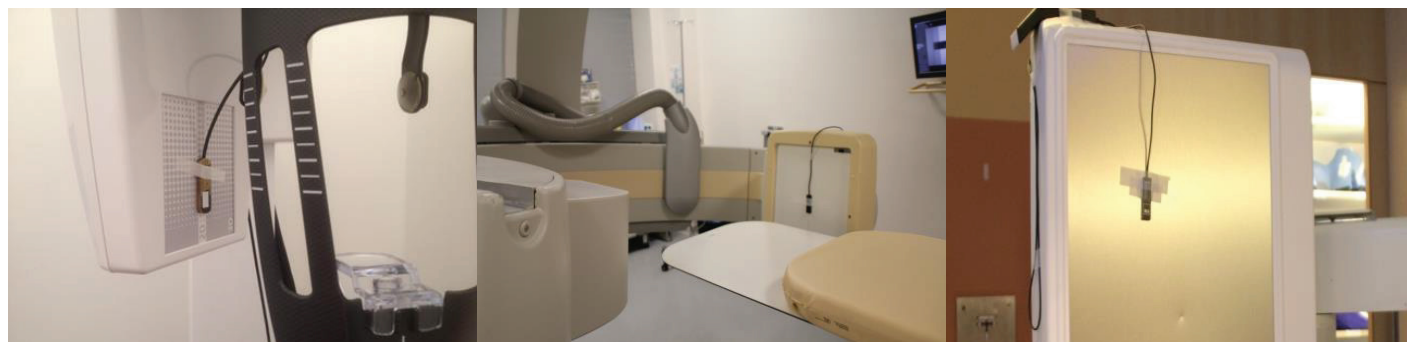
Position of a flat solid-state probe to measure the $K_{a,i}$ (FDD) in a dental CBCT (left), a C-arm for angiography CBCT (center) and a CBCT in radiotherapy (right). Images courtesy of F. Schöfer, B. Renger and K. Mair.
